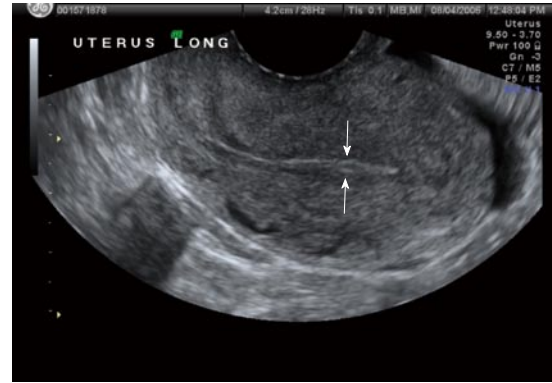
Transvaginal ultrasound image of a thin endometrial echo associated with and ectopic pregnancy.
